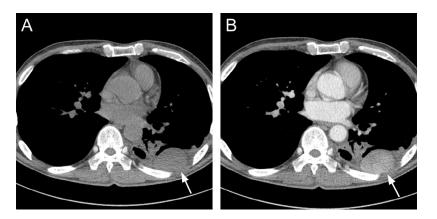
Contrast-enhanced CT of pleural Castleman's disease. (A) Precontrast CT scan shows a pleural-based mass lesion (arrow) in the posterior left hemithorax at the level of the 8th rib measuring approximately 4.5 × 3.5 cm in axial dimensions. (B) Contrast-enhanced image shows homogenous avid enhancement of the mass. CT, computed tomography.
